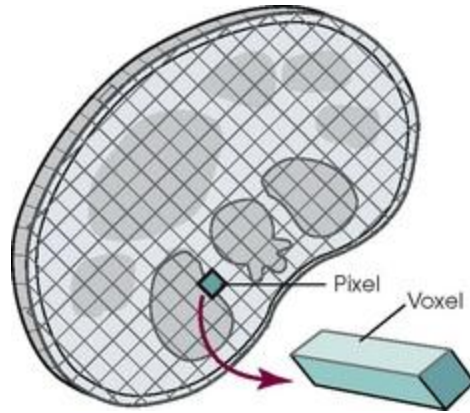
Demonstrates the Main component of CT image
